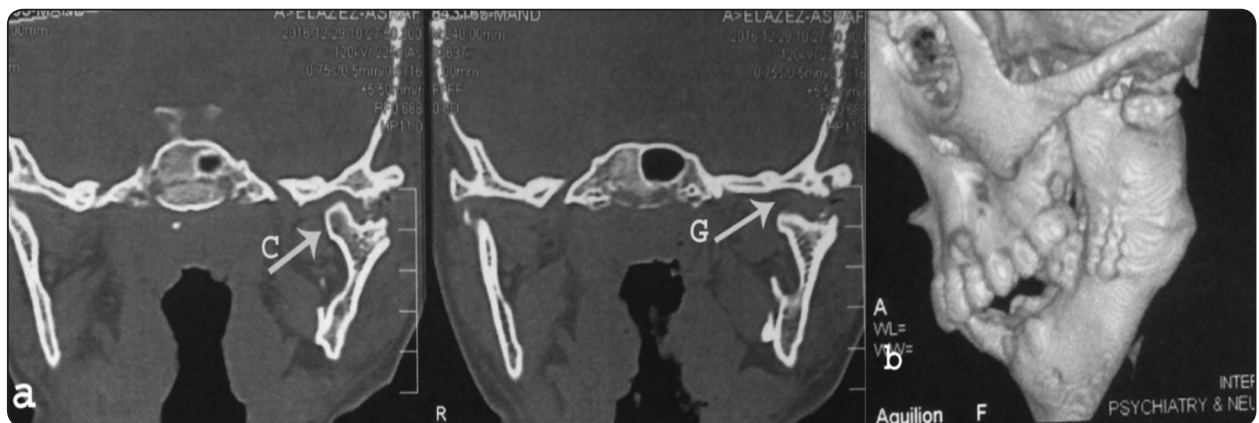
Postoperative a. coronal CT showing complete release of the Lt joint after excision of the lateral callus and creation of enough bony gap (G arrow); note the condyle in a good relation to the glenoid fossa (C arrow).b. 3-D CT of the same patient.
